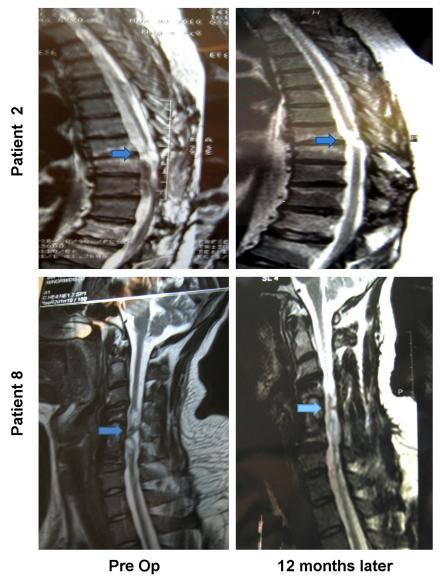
Magnetic resonance images of thoracic (patient 2) and cervical (patient 8) spinal cord before and 12 months after transplantation. No evidence of neoplastic tissue overgrowth, syringomyelia or psuedomeningocele was seen.
